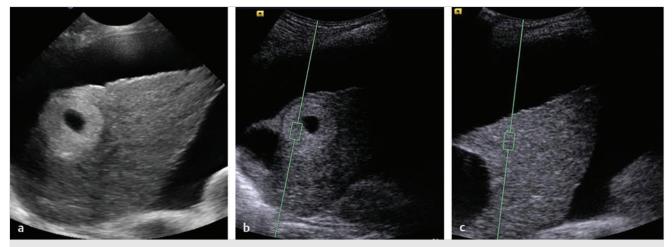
Point shear wave elastography of the liver and a focal liver mass. The patient is a 41-year-old male with hepatitis B virus–related cirrhosis and a known renal cell carcinoma of the kidney. (a) Baseline ultrasound shows a cirrhotic liver and ascites. An unusual mass shows a highly echogenic rim and a necrotic or cystic center. (b) shows an ARFI measurement from the solid rim, V_s 1.09 m/s. (c)The measurement at a similar depth in the liver shows an abnormally high result, consistent with the known cirrhosis. The mass is softer than the cirrhotic liver. The mass is a biopsy proven hepatocellular carcinoma.
